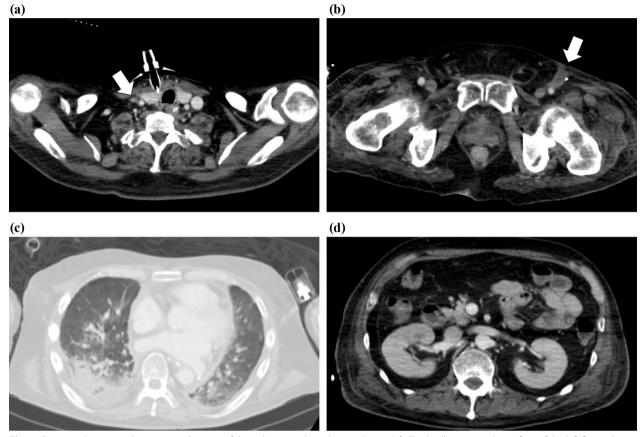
Computed tomography images. a Stenosis of the right internal jugular vein (arrows). b Fluid collection on the surface of the left femoral vein (arrows). c Consolidation and atelectasis of the lungs. d Normal-sized kidneys
